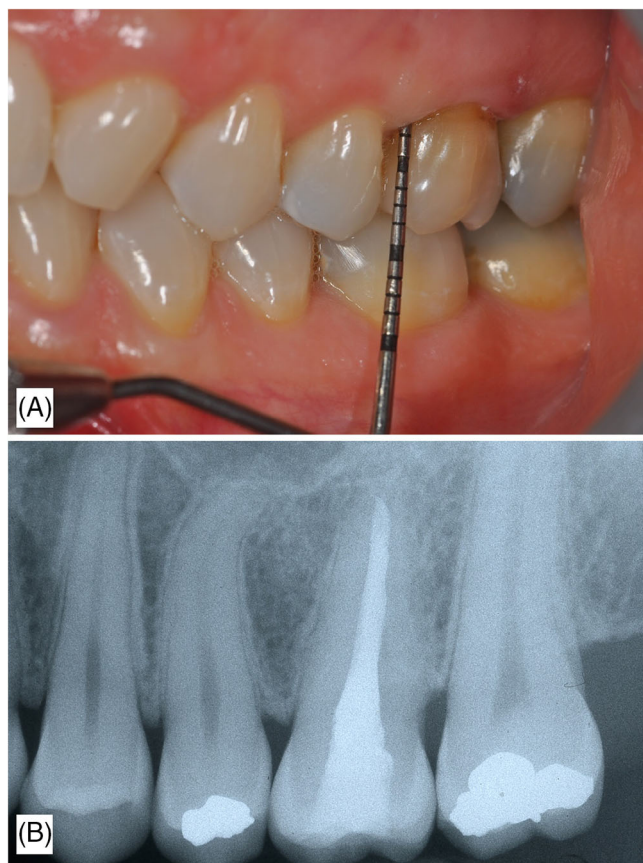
Clinical (A) and radiographic (B) evaluations 10 years after autotransplantation.
